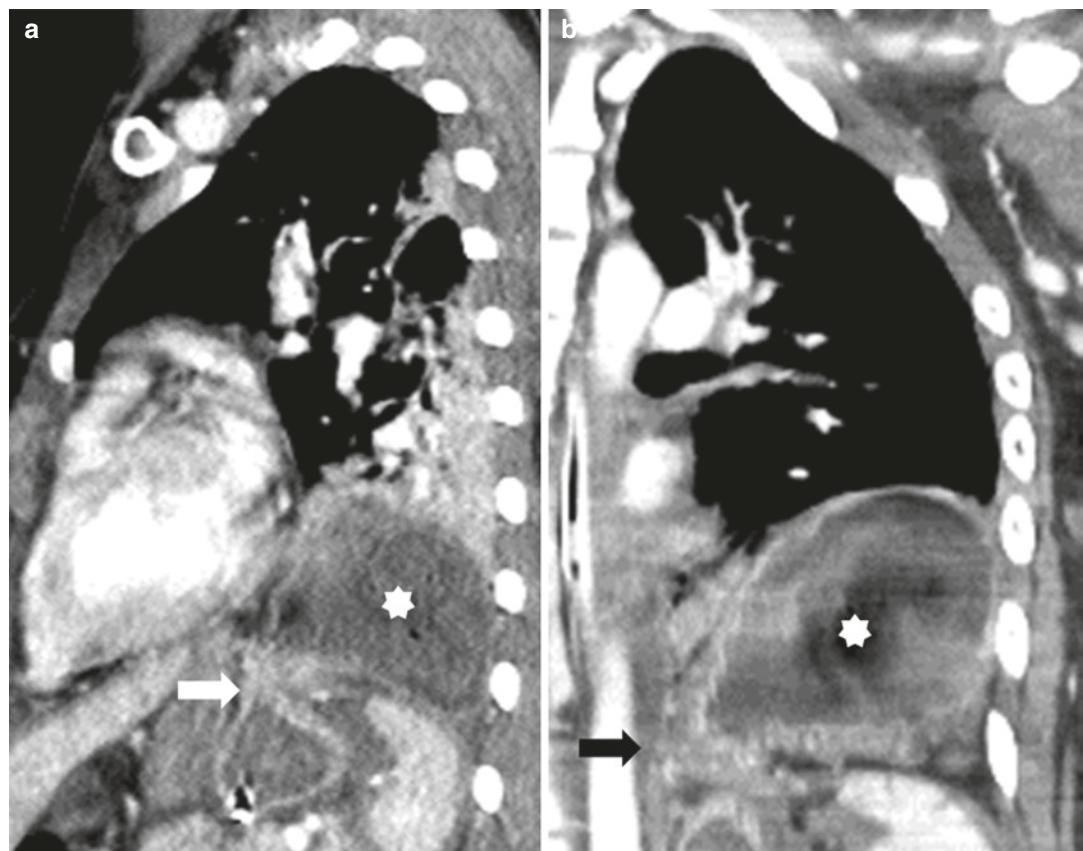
Nineteen-year-old woman presenting after MVC. Sagittal (a) and coronal (b) contrast-enhanced CT images show left diaphragm injury (white and black arrows), with superior herniation of the stomach (asterisks)
